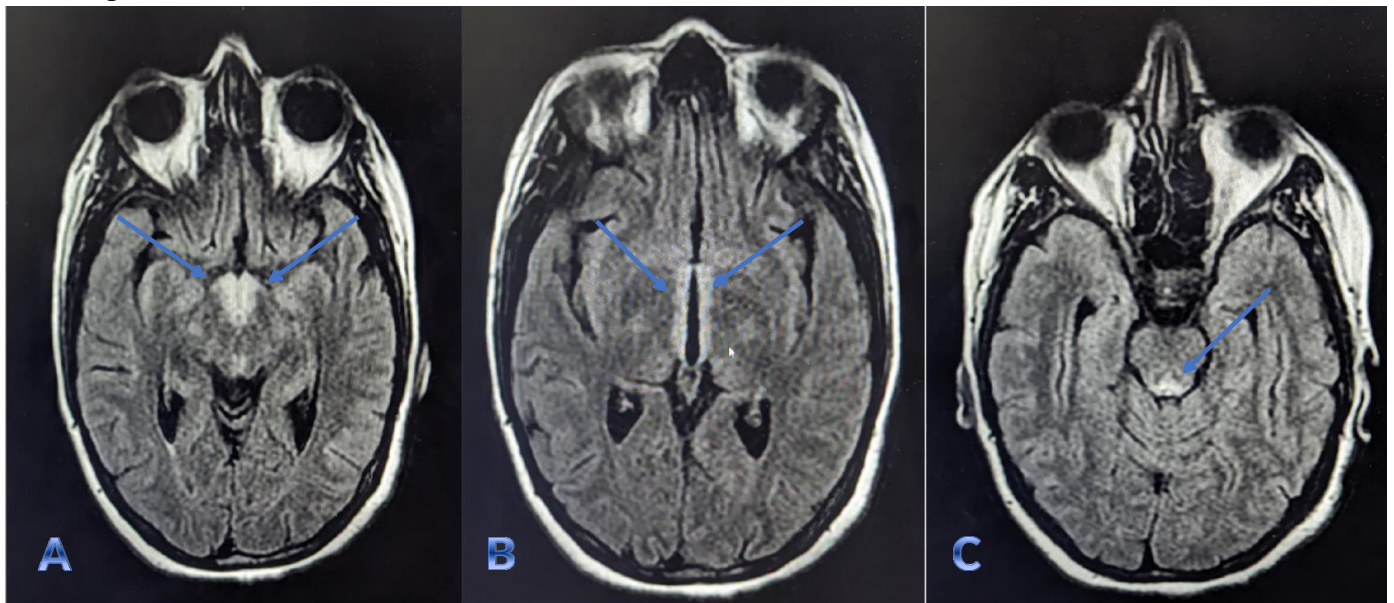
Axial MRI T2 FLAIR sequences showing hyperintensities of the medial thalami (A and B) and the periaqueductal region (C).
